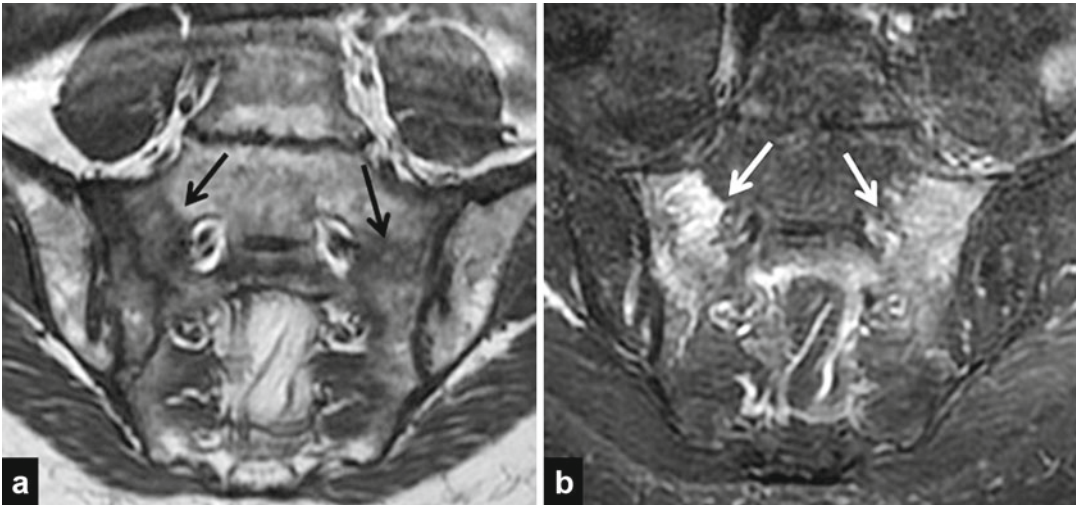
Bilateral fracture of the sacrum. (a) T1-weighted image shows the fracture as a hypointense line (*black arrows*). (b) T2-weighted fat-saturated image shows the fracture line surrounded by intense edema (*white arrows*)
